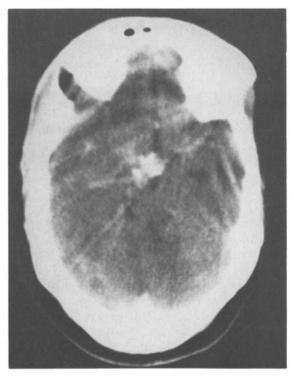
Postoperative enhanced CT scan demonstrates residual, solid, calcified tumor in the suprasellar cystern.
